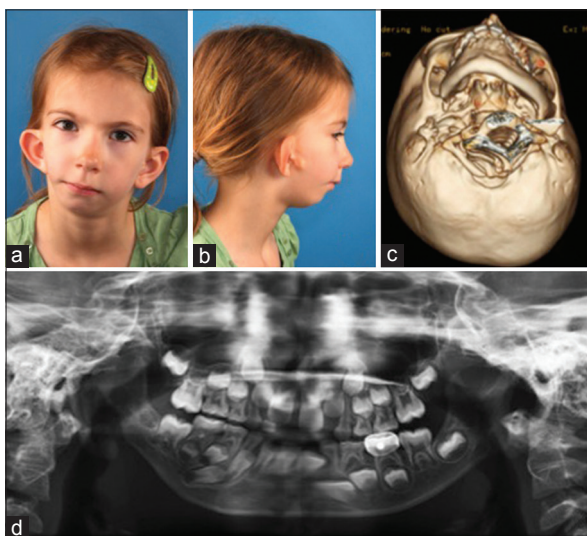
Pruzansky-Kaban Type IIb. The mandibular ramus is hypoplastic and markedly abnormal in form and location, being medial, anterior and inferior. There is no articulation with the temporal bone. (a) Frontal view of an affected adolescent; (b) profile view of the affected side of the girl in (a); (c) three-dimensional (3D) reconstruction of a multi-slice computed tomography (CT), submento-vertical view, demonstrating the abnormal location of the mandibular structures in abnormal location (the same patient as in (a) and (b)); (d) orthopantomogram of the girl in (a), (b), and (c), showing downward growth of the skull base on the affected side and no articulation
